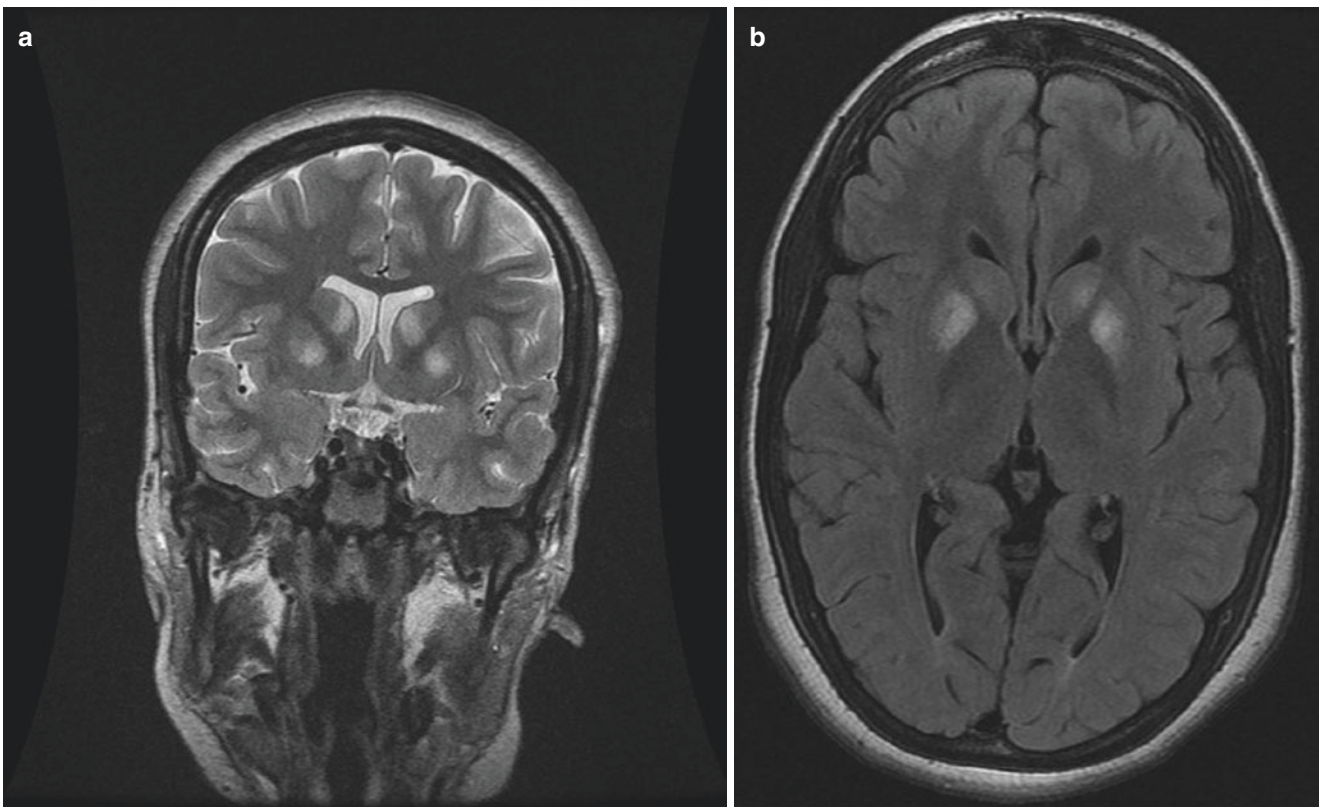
(a, b) Coronal T2 weighted sequence (a) and axial FLAIR sequence (b) of the brain reveals hyper intensity of bilateral basal ganglia secondary to copper deposition in Wilson's disease
